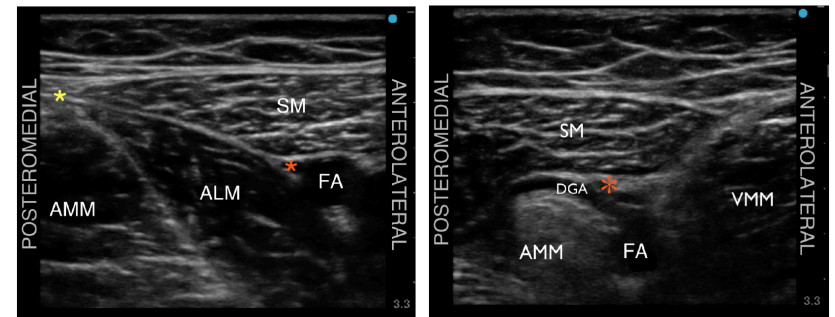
Ultrasound image demonstrating the femoral triangle apex. This point was confirmed to lie distal to the femoral triangle injection point. Red asterisk: endpoint target for needle tip; yellow asterisk: alignment of medial borders of sartorius and adductor longus muscles. ALM, adductor longus muscle; AMM, adductor magnus muscle; FA, femoral artery; SM, sartorius muscle.
